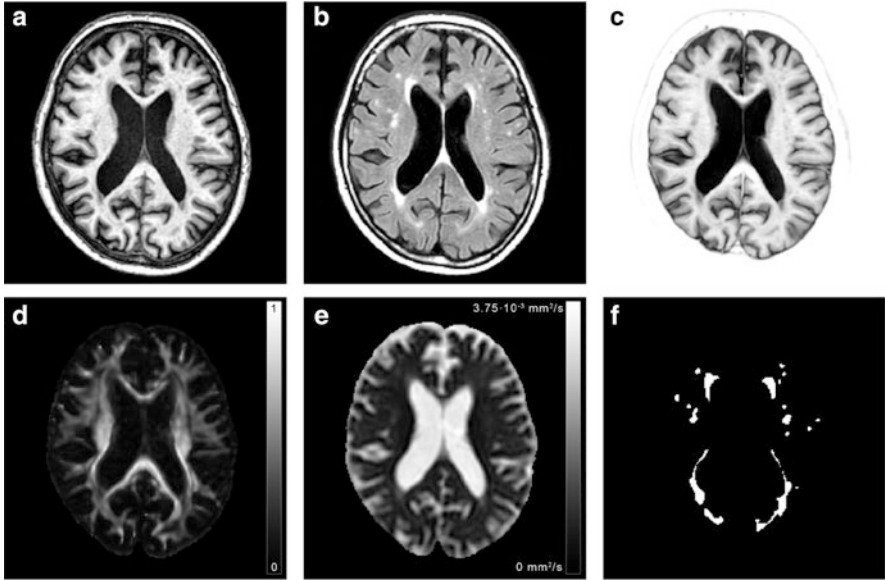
Example image data of a subject with a high white matter hyperintensity (WMH) load (WMH volume: 34 ml). The *top row* shows the intensity features, where WMH appear *dark* on T1 and IR, and *bright* on FLAIR. *Bottom row* shows diffusion features, where WMH appear *dark* on FA and *bright* on MD, with the manual delineation of the WMH. (a) T1; (b) FLAIR; (c) IR; (d) FA; (e) MD; (f) Manual delineation
